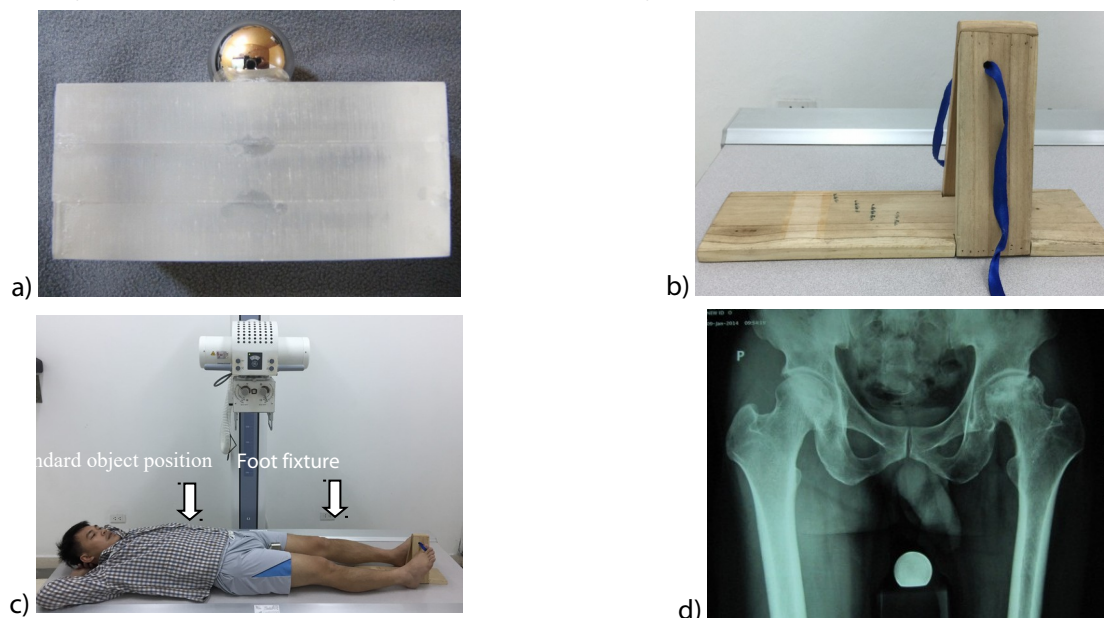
Standard object and radiographic position for bilateral straight hip
